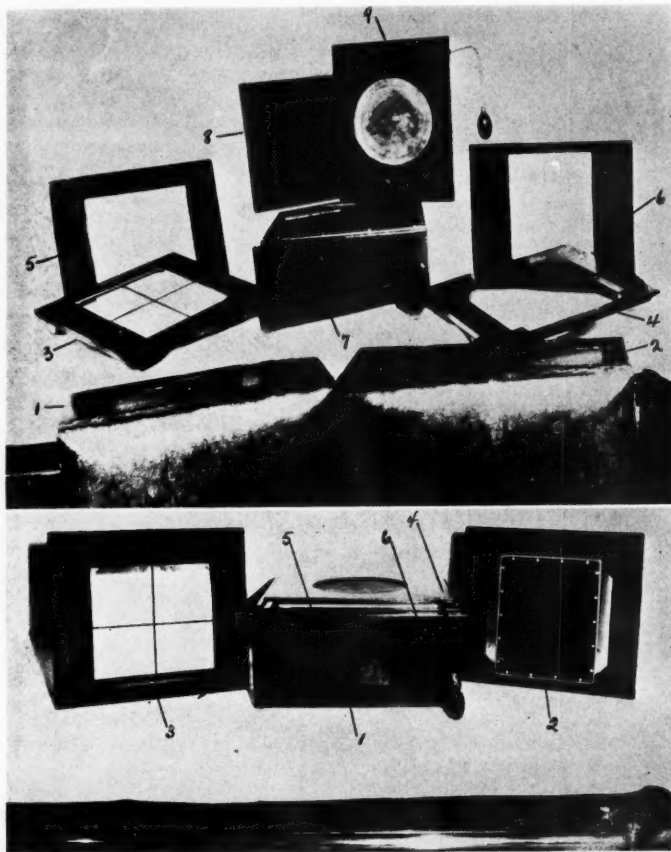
(above). Unit with accessories for gastro-duodenal radiography: (1) and (2) comfortably padded Bucky cushions; (3) fluoroscopic screen with centering wires mounted in wooden frame; (4) wooden frame cassette holder; (5) stomach mask for transverse type; (6) stomach mask for vertical type; (7) unit in horizontal position with leg attached; (8) Lysholm grid, and (9) compression device.
